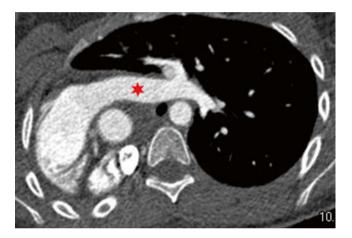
Axial CT shows dextroposition of the heart. The left pulmonary artery is shown (*), but there is agenesis of the right pulmonary artery. The right lung is congenitally absent
